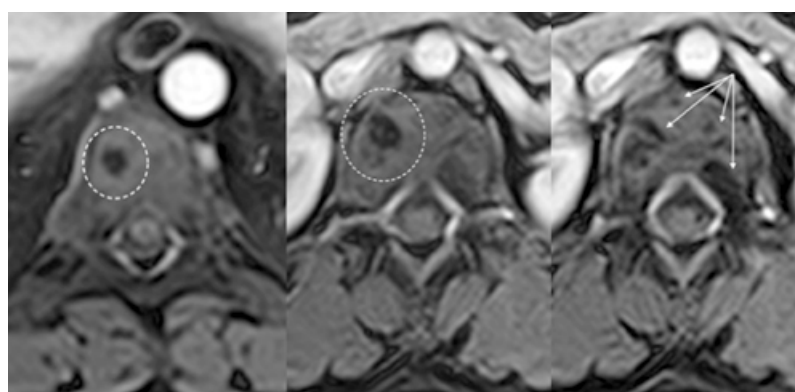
Contrast Enhanced T1 WI MR images of the lower thoracic and lumbar vertebrae present consecutive axial slices. Low-signal intensity foci that do not accumulate contrast material after dynamic intravenous contrast enhancement are encircled by a broken line and arrowed.
